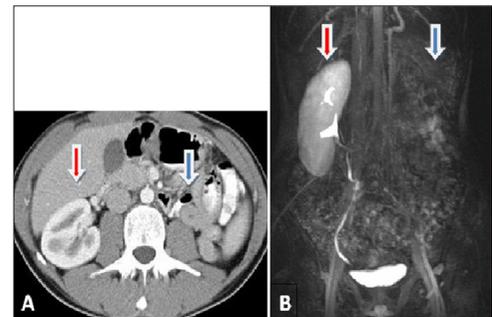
Left renal agenesis (blue arrow) and compensatory hypertrophy of right kidney (red arrow) on contrast-enhanced computed tomography (A) and magnetic resonance pyelography (B).
